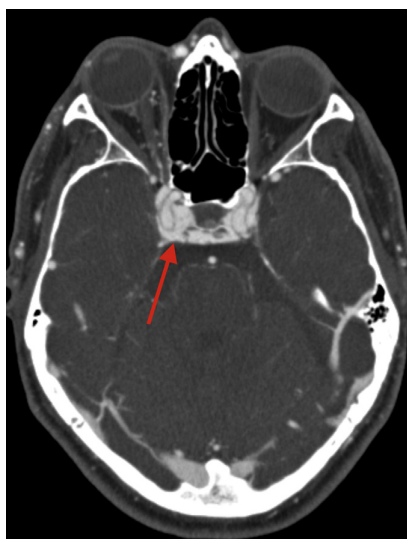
CT angiography (axial view) demonstrating arterial phase filling of the cavernous sinus (arrow).
